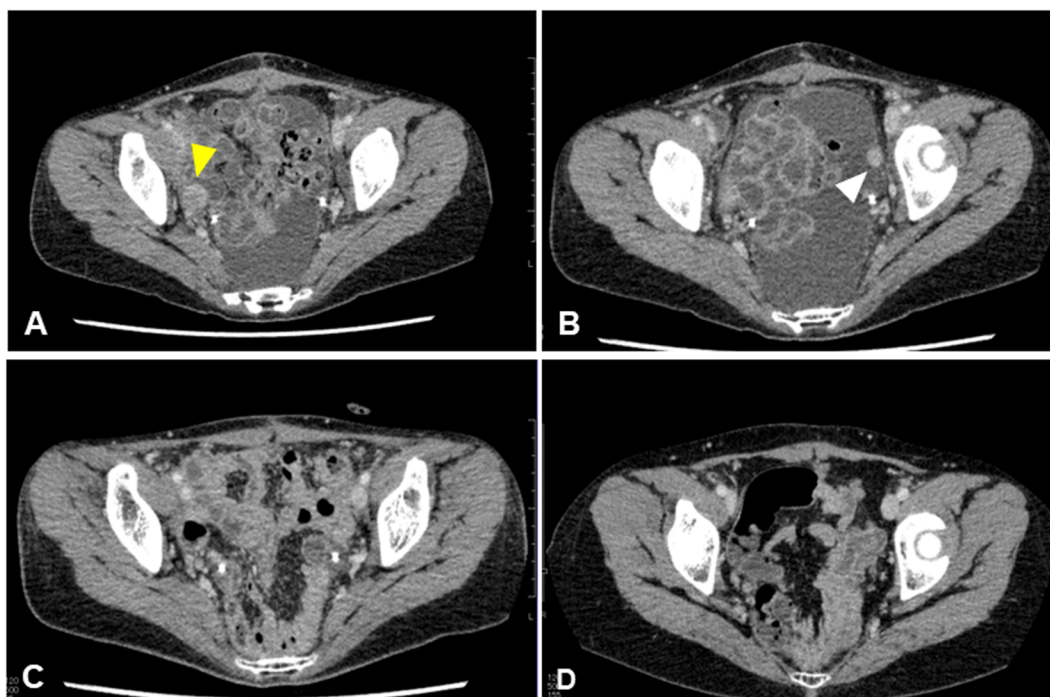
At three weeks after the surgery to optimally debulk the tumor, computed tomography (CT) showed swelling of the right obturator lymph node (yellow arrowhead) (A), and ascites in the pelvic cavity, peritoneal dissemination (white arrowhead) (B). After completion of chemotherapy (paclitaxel, carboplatin, and bevacizumab), swelling of right obturator lymph node was decreased (C), and CT showed neither ascites nor peritoneal dissemination (D).
